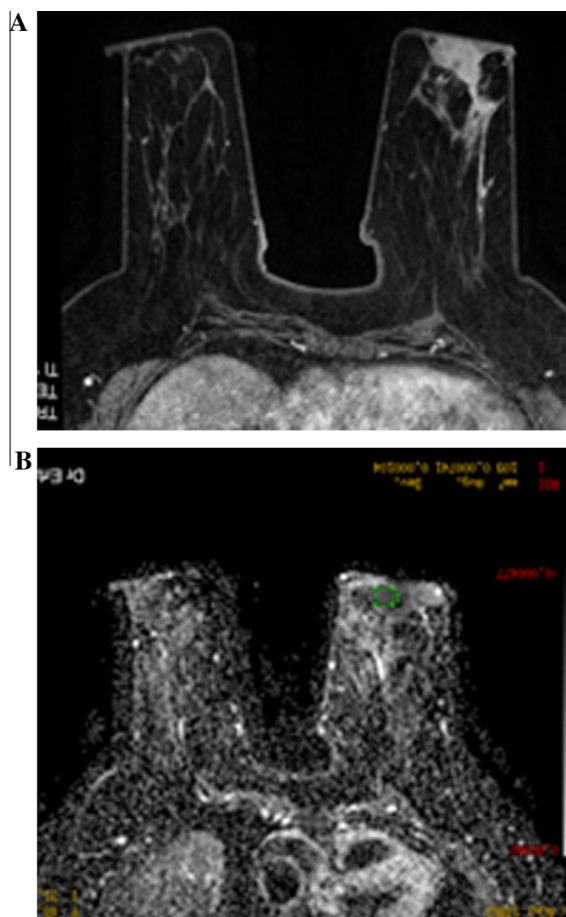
A – DCE-MRI shows an inhomogeneously enhancing retroareolar mass lesion with spiculated margins. B – ADC map revealed restricted diffusion with a low mean ADC value of $0.7 \times 10^{-3} \text{ mm}^2/\text{s}$.
